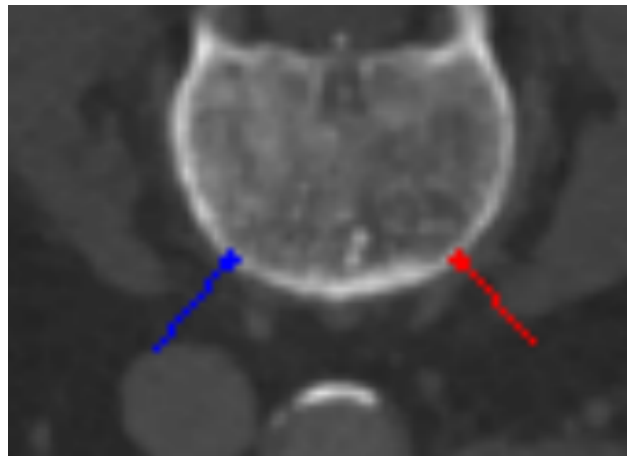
The entire vertebrae shown in this image is diseased. The hardened trabecular bone density on each side cancels the other out so the region is not marked as diseased. The underlying CT data is from the Addenbrooke's Hospital CT Data Collection.
